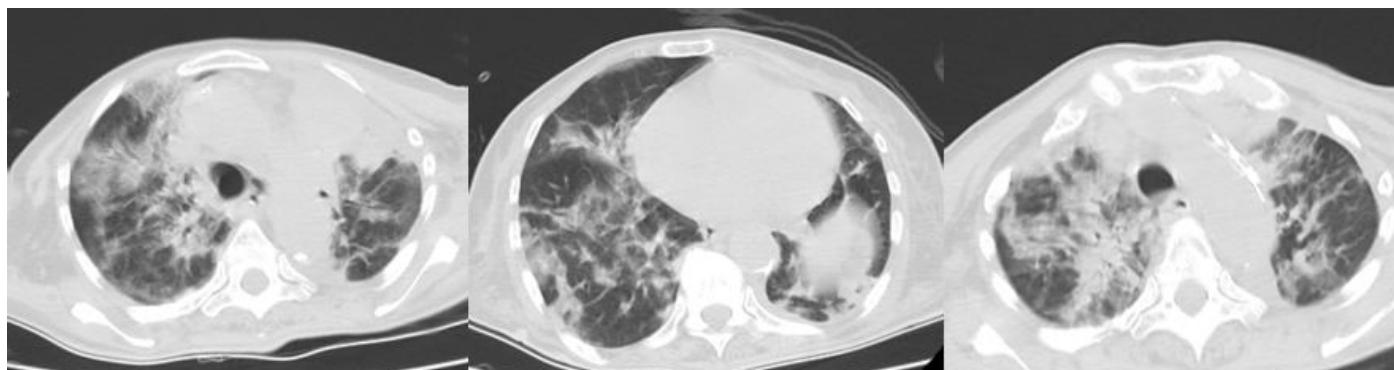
Thorax computed tomographic imaging
